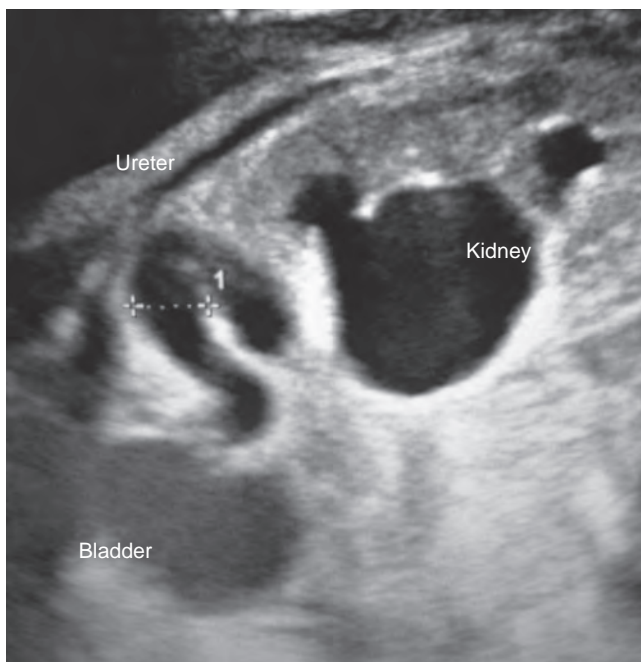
Prenatal ultrasound image showing hydronephrosis.
